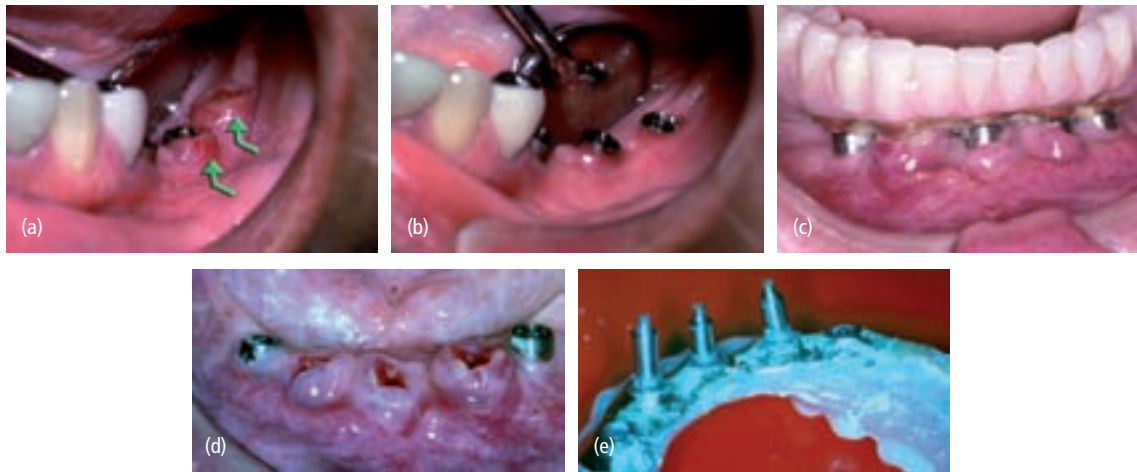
(a) Note the irregular, unhealthy tissue that proliferated around these implants where loose abutment screws were present. (b) Retightening the abutment screws created a significant improvement in the soft tissues in 2 weeks and the tissue subsequently returned to normal appearance with no radiographically discernible changes. (c) Multiple abutment screws have fractured and the resulting gaps between the parts allowed bacterial accumulation to occur, resulting in gingival hyperplasia. (d) The prosthesis has been removed, revealing the condition of the soft tissue. (e) The undersurface of the prosthesis showing the abutments with fractured screws attached to the prosthesis. (c–e: Courtesy of Dr R. Yanase.)
